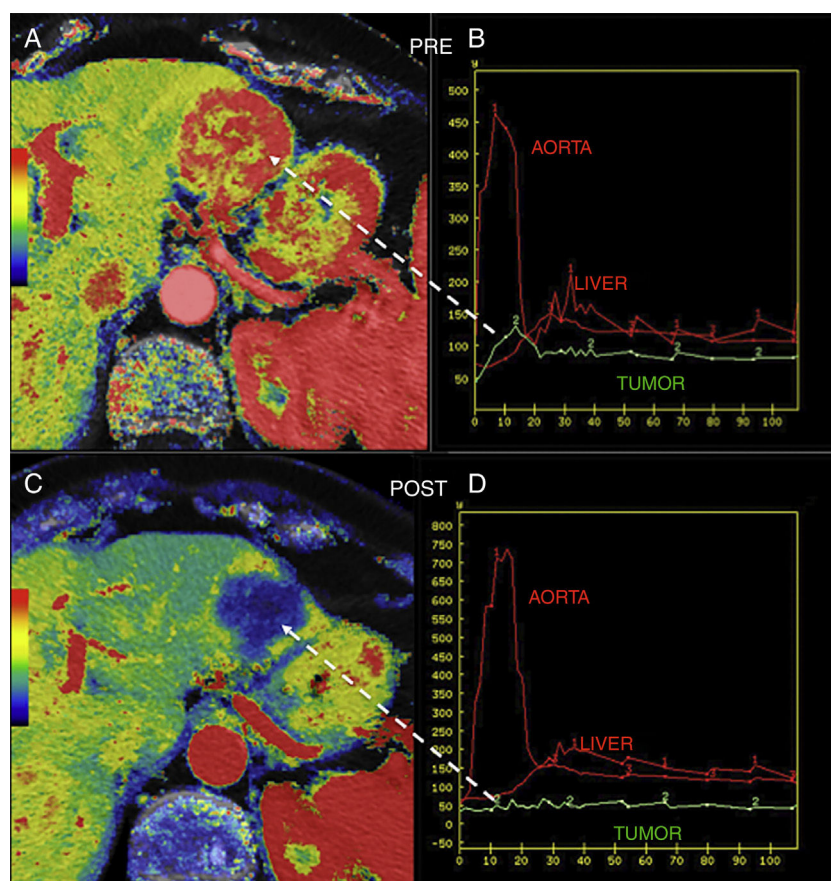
Hepatic metastasis of pancreatic neuroendocrine tumor treated with antiangiogenic therapy. Parametric maps of blood flow pre-treatment (A) and 15 days after angiogenic therapy (C) overlapping the anatomical image of a CT scan (50% transparency) and uptake curves of the metastatic lesion (in green), the aorta and the normal hepatic parenchyma (B and D) showing significant tumor response with a drop of metastatic flow from 118 ml/100 g/min to 8 ml/100 g/min and change in the morphology of the enhancement curve of the lesion from one enhancement curve with washout (type 3) (B) to one plane curve with almost no changes (D).
